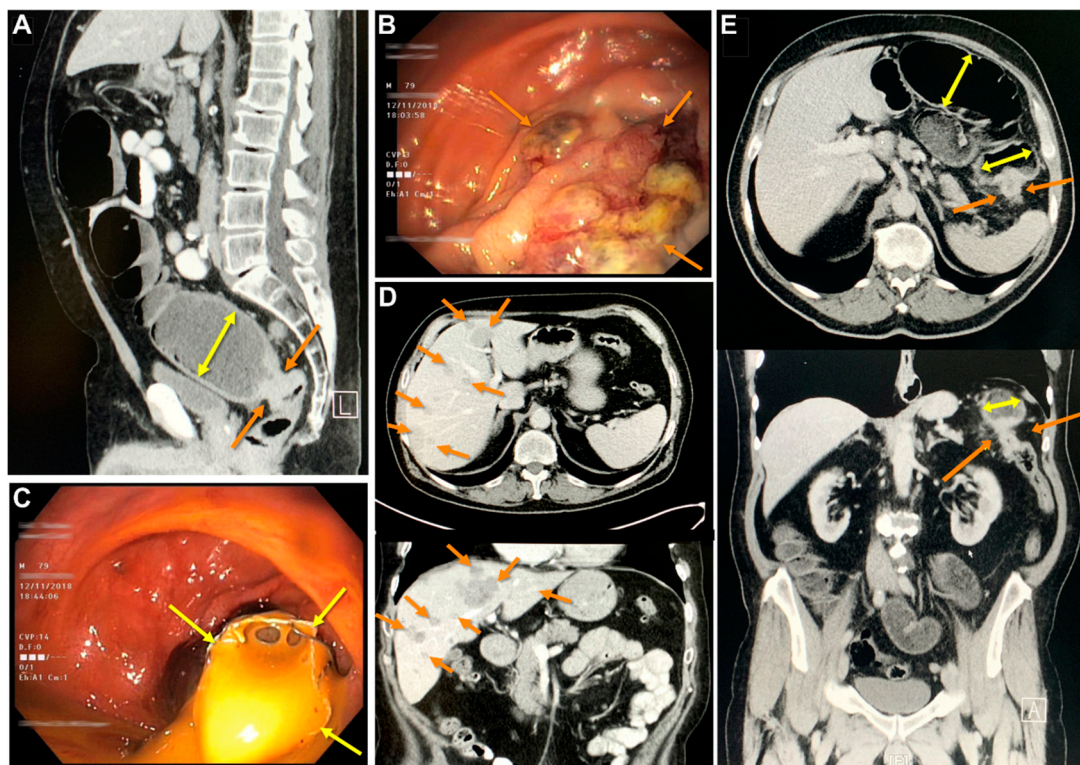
Clinical imaging derived from the two donors of the colorectal cancer cell lines. Patient BKZ-2: (A) Computerized tomography (CT)-scan with demonstration of a rectal stenotic mass (orange arrows) with pre-stenotic obstructed bowel (yellow double arrow). Endoscopic appearance of carcinoma BKZ-2 (B) with intestinal discharge following (C) endoscopic bowel stenting of the neoplastic stenosis. (D) Staging CT-scan visualizing hepatic metastases (orange arrows). Patient BKZ-3: (E) CT-scan indicating the neoplastic mass of the left colon (orange arrows) with pre-stenotic obstructed bowel (yellow double arrows).
